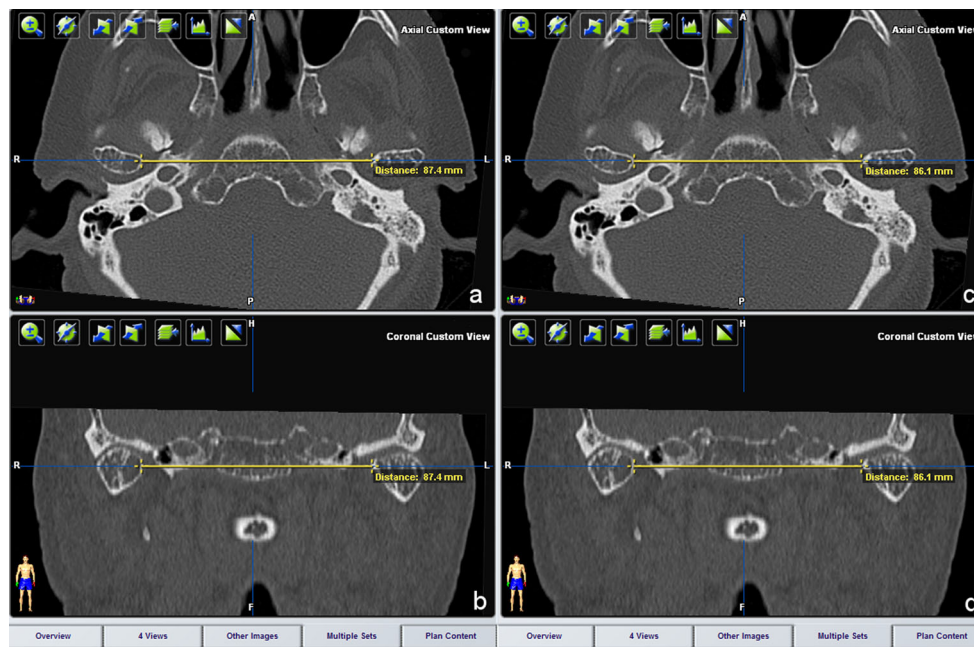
Measurement of distance between the innermost points of the left and right condyles in iPlan® CMF 3.0. Left preoperative CT image, a shows axial plane, b shows coronal plane. Right postoperative CT image, c shows axial plane, d shows coronal plane. The yellow lines
